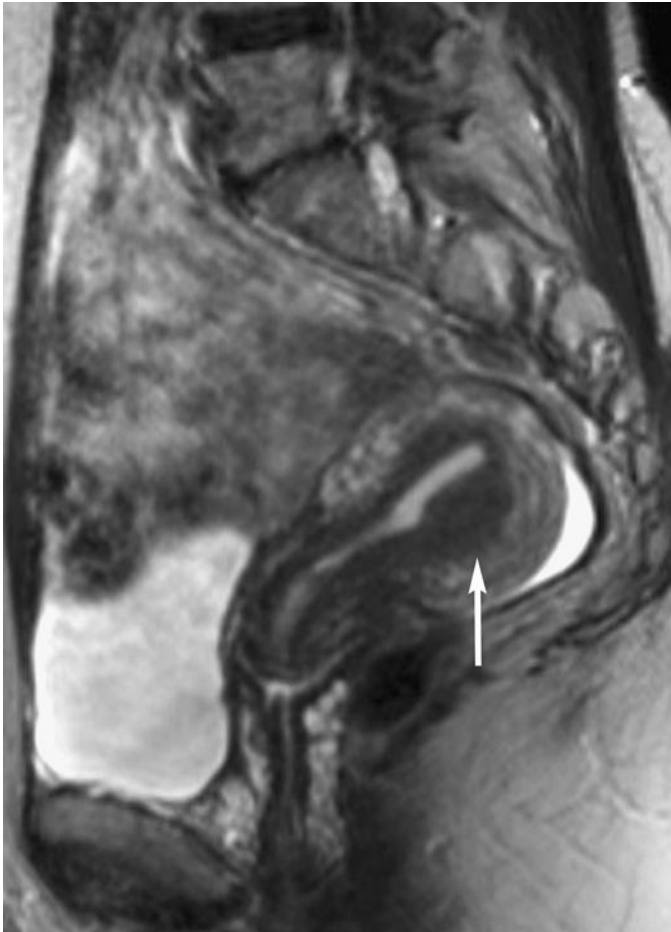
Focal adenomyosis. Sagittal T2-weighted image demonstrates a region of focal thickening of the junctional zone (arrow) with indistinct margins.
